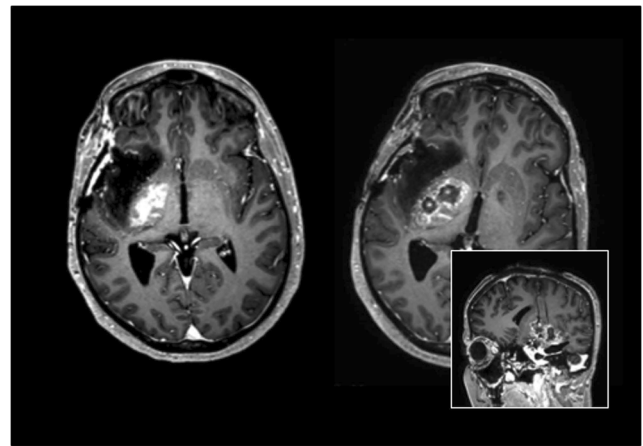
Patient 10. MR images before and after 5 days of treatment. Catheters are removed, but very localized fibrosis and circular necrosis were visible where the catheters were inserted
